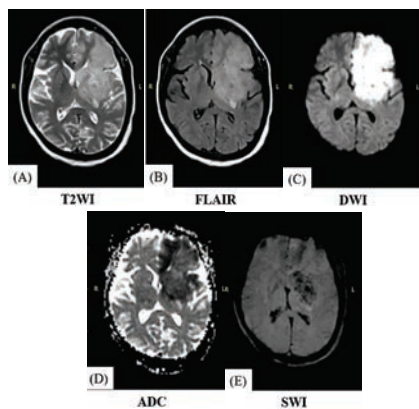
26-Year-Old Male with Dengue Encephalitis. Axial T2-Weighted image (A) and a Axial FLAIR Image (B) Showing Hyperintensity Involving the Left Frontal Lobe, Capsulo-Ganglionic Region with Thalamus, with Areas of Restricted Diffusion Apparent on DWI (C) and Apparent Diffusion Coefficient Maps with an Associated Mass Effect, as Evidenced by Effacement of the Frontal Horn of the Left Lateral Ventricle. Multiple Hemorrhagic Foci Can Seen Within the Lesion on SWI Sequence (E)
